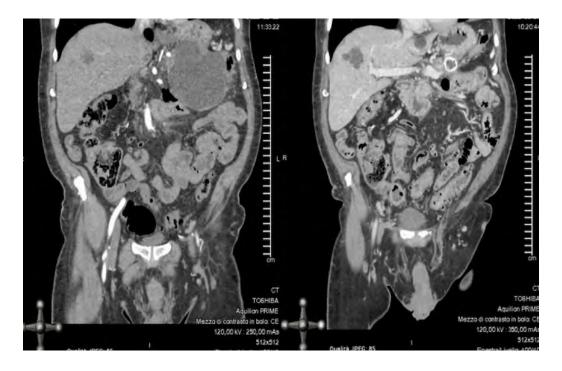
CE-CT scan showing the endoscopic positioning of a trans-gastric AXIOS drain within a large infected necrotic collection, as the second step of a step-up endoscopic approach.
